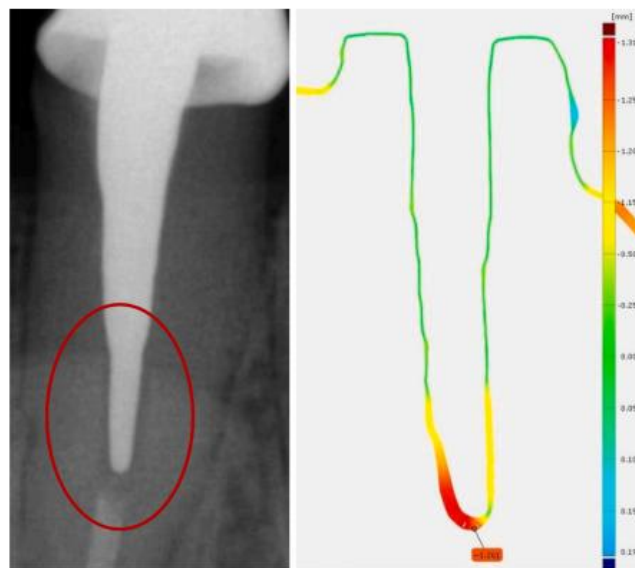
Left: X-Ray after cementation of CPC showing insufficient accuracy of fit in the apical area (red circle). Right: Analysis of the deviation between post impression methods showing a higher impression depth for the digital post impression (negativ values).
